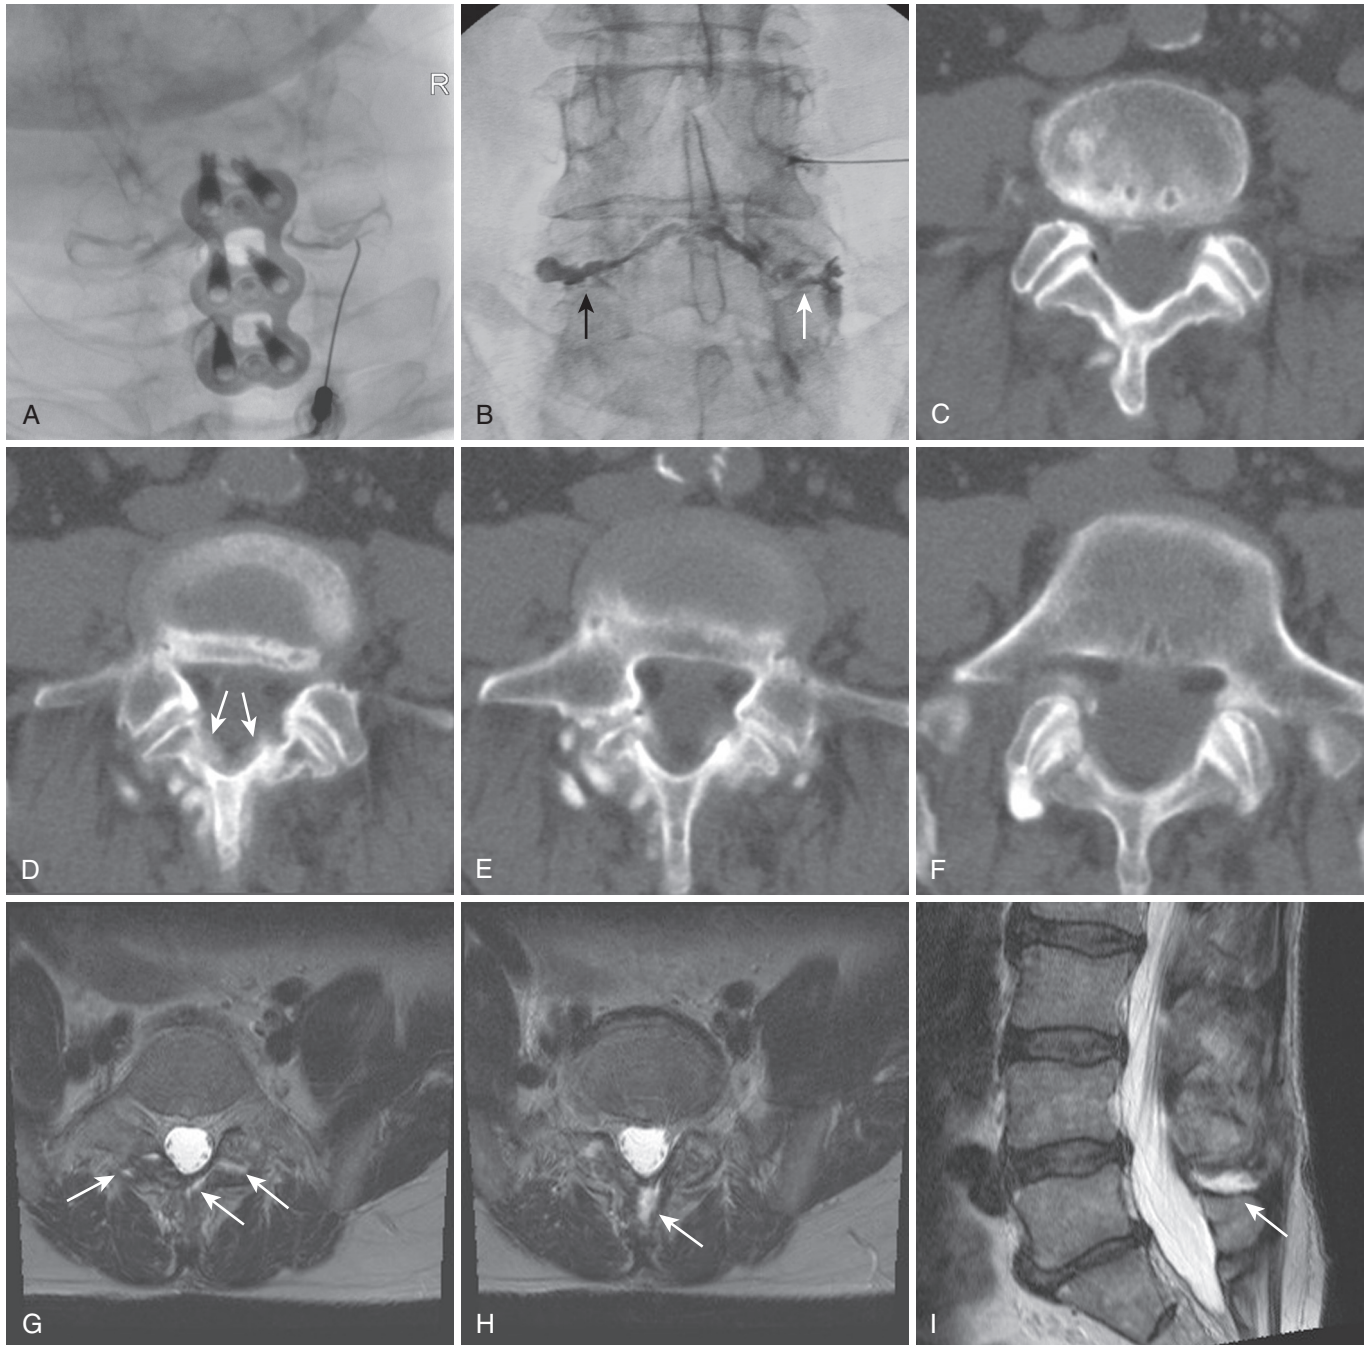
The Space of Okada. Frontal fluoroscopic image (A) demonstrates the space of Okada providing communication between the bilateral C6-7 facets via the right-sided injection. In another patient (B), an attempted right L4 transforaminal injection opacified the superior recess of the L4-5 facet, traversed an L5 pars defect (white arrow) to the right L5-S1 facet, and opacified the space of Okada to a left L5 pars defect (black arrow) and the left L4 and L5 facets. Subsequent CT (C, D, E, F) confirms opacification of all these structures. The space of Okada is marked by the white arrows in (D). The space of Okada may contain a small amount of fluid, which appears as T2 hyperintensity (white arrows, G, H, I). Note continuity with interspinous ligament (arrow in [H] and [I]).
